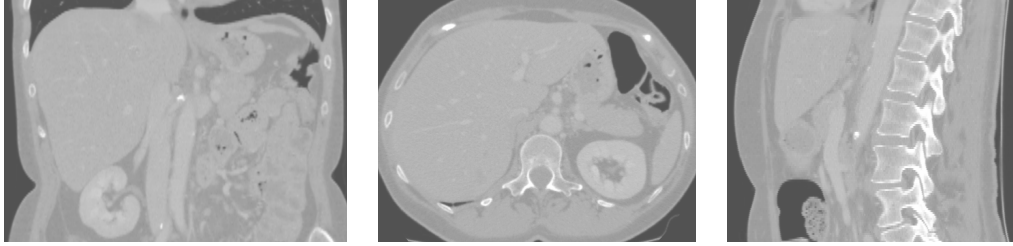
Three views of a CT image of the liver.
